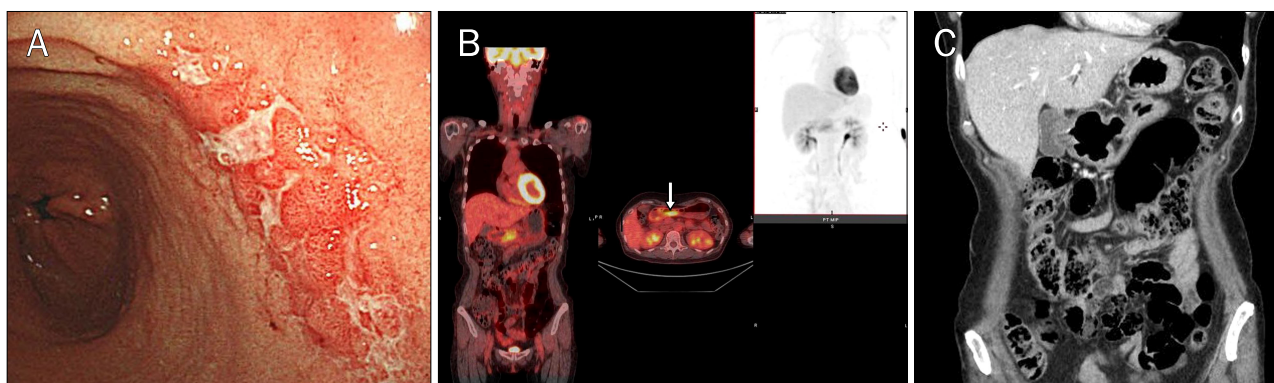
This case shows the fluorine-18 fluorodeoxyglucose (F-18 FDG) uptake in an erosive-ulcerative type of gastric mucosa-associated lymphoid tissue lymphoma. (A) A 56-year-old female patient had an erosive-ulcerative lesion on the antral posterior wall of the stomach. (B) Maximum standardized uptake value of F-18 FDG uptake (arrow) was 6.2. (C) Abdomen CT shows irregular wall thickening at the gastric antrum.
